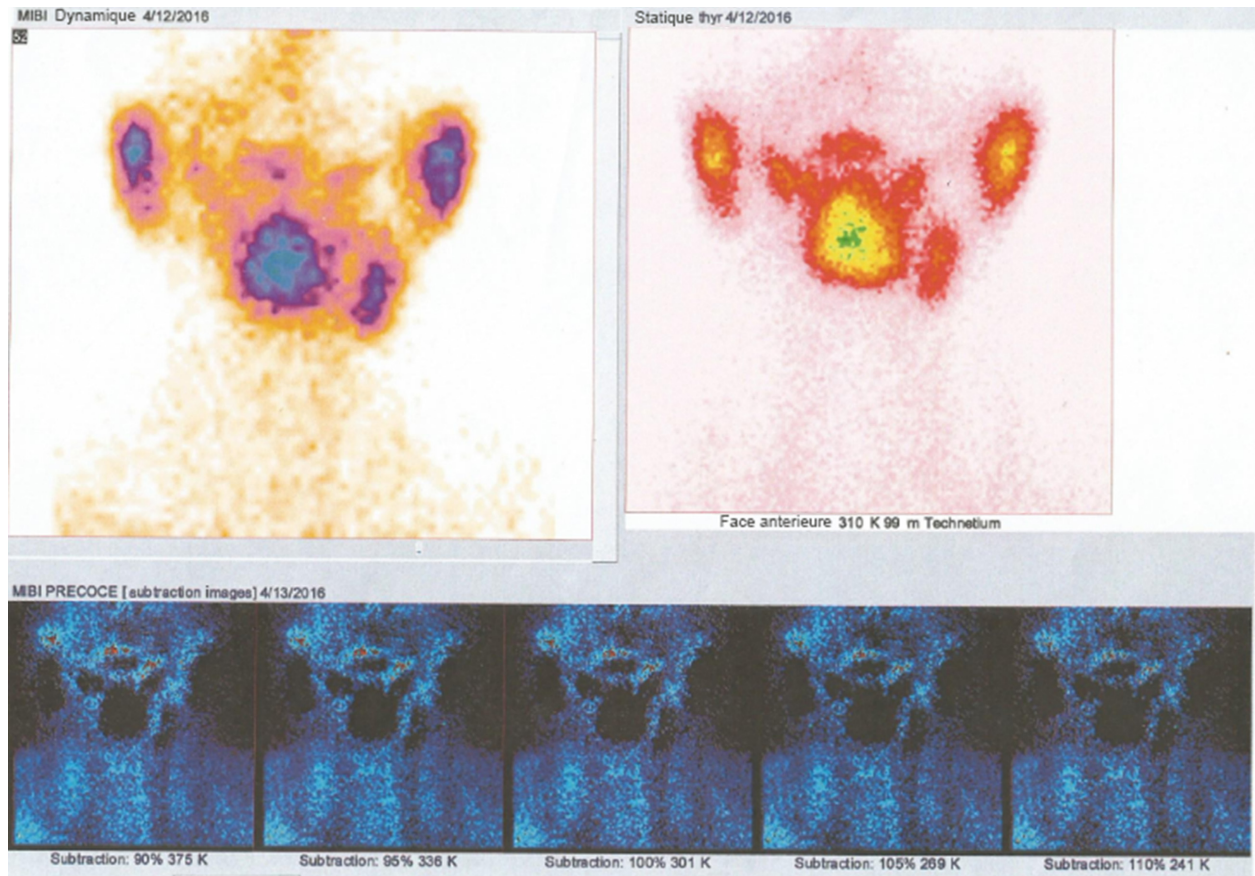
Parathyroid scintigraphy with dual-isotope subtraction imaging technique (99mTc-pertechnetate and 99mTc-MIBI radiopharmaceuticals): High uptake in the salivary gland without any parathyroid tissue.
